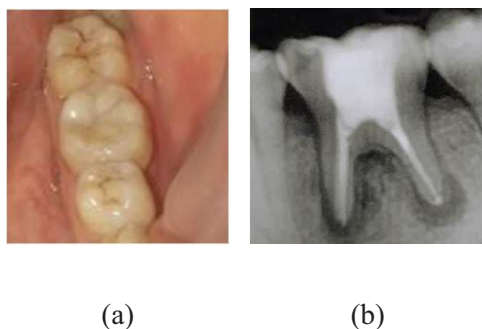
(a). The final restoration, (b). Radiograph showing coronal seal of tooth 36
